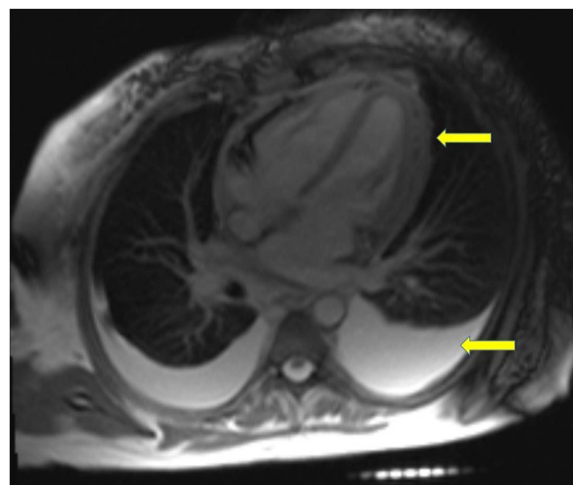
Cardiac MRI. Diffusely thickened pericardium 5 mm and pleural effusions demonstrated on cardiac MRI (see arrows).
